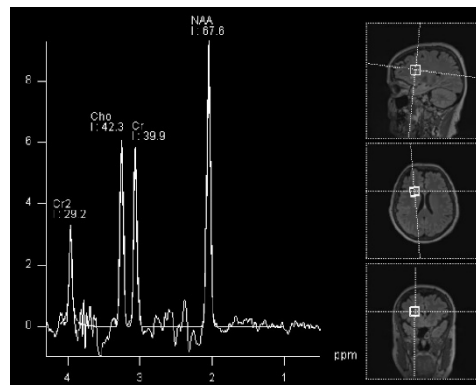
MRI presents the levels of NAA exceeding choline indicating a healthy brain [27].
